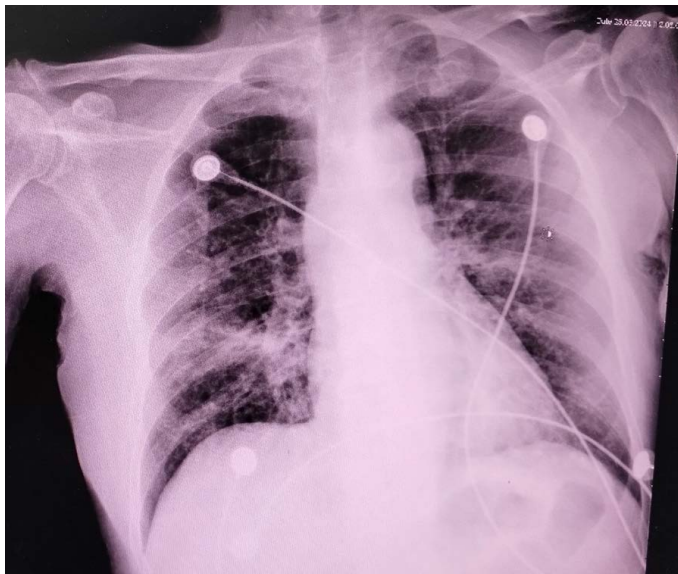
Admission frontal projection expiratory film (AP view) Chest Xray.
